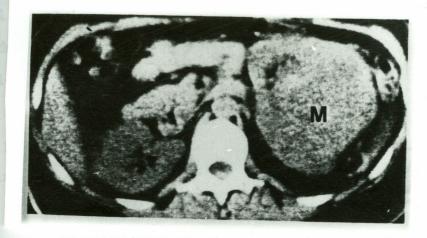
Renal cell carcinoma. Precontrast CT scan shows a large mass (M) arising from the posterolateral surface of the left kidney. In addition to diagnosis and staging C.T. plays important role in the follow-up of these patients who are treated with surgical resection, especially who are at risk of post operative recurrence benefit most from follow-up C T. Extensive bulky renal tunours, and lymph node of ipsilateral adrenal metastosis all place the patient at risk for recurrence. Early detection of local recurrence would allow prompt surgical resection. Features that suggest recurrence are a large soft tissue mass in the renal fossa, enlargement or irregularity of the psoas muscle on the side of the resction, and other local organ involvement.
